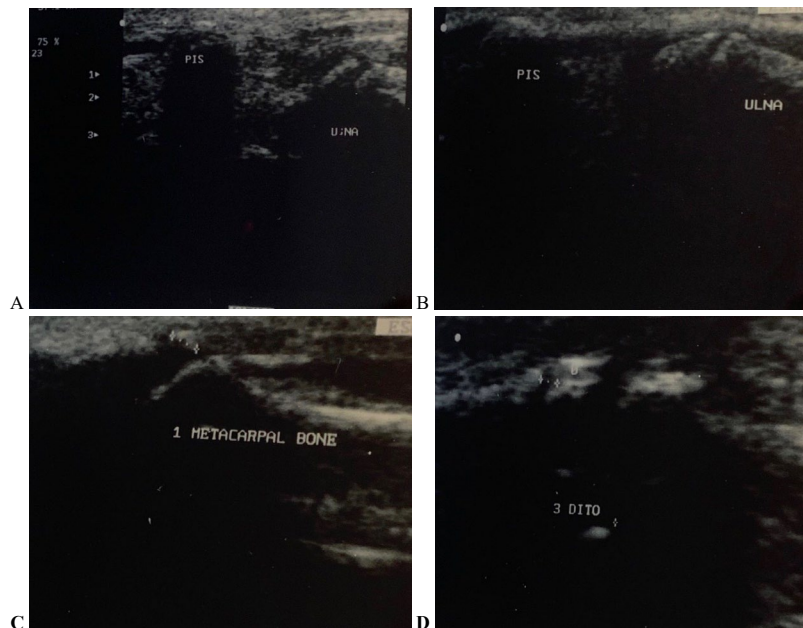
A)* Wrist ultrasound during the puberal growth peak. Initial ossification of the pisiform nucleus, that becomes apparent as a hyperechoic area node determining an acoustic shadowing: it is located within the hyperechoic area corresponding to the cartilaginous portion of the nucleus. The ulnar epiphysis can be well appreciated too, together with its nucleus and with the growth cartilage, that is still present. *B)* Wrist ultrasound of the pisiform in a more advanced growth phase. The nucleus becomes very large, with respect to the previous scan, and it gives onset to a sharp cone of acoustic shadowing. *C)* Wrist ultrasound: the ossification center of the adductor tendon of the thumb becomes apparent as a hyperechoic spot with a cone of acoustic shadowing located within the tendon sheet: compare these ultrasound findings with the corresponding x-ray pictures. *D)* Hand ultrasound before the end of the puberal growth peak. The cortical profile of the distal phalanx of the third finger is interrupted by a hypoechoic band (calipers) which corresponds to the growth cartilage: this finding may be better appreciated on the x-ray film.
